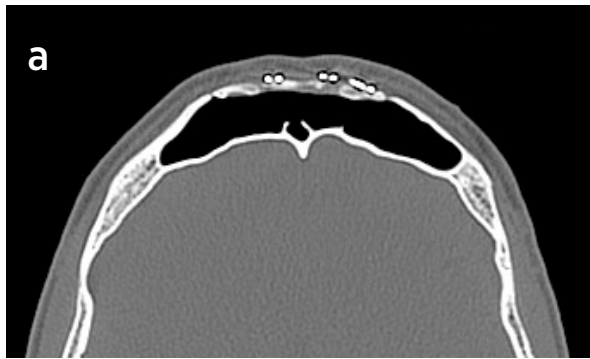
a, b. Computed tomographic scan 5 months after the surgery shows a good contour of the frontal bone and aired frontal sinus
